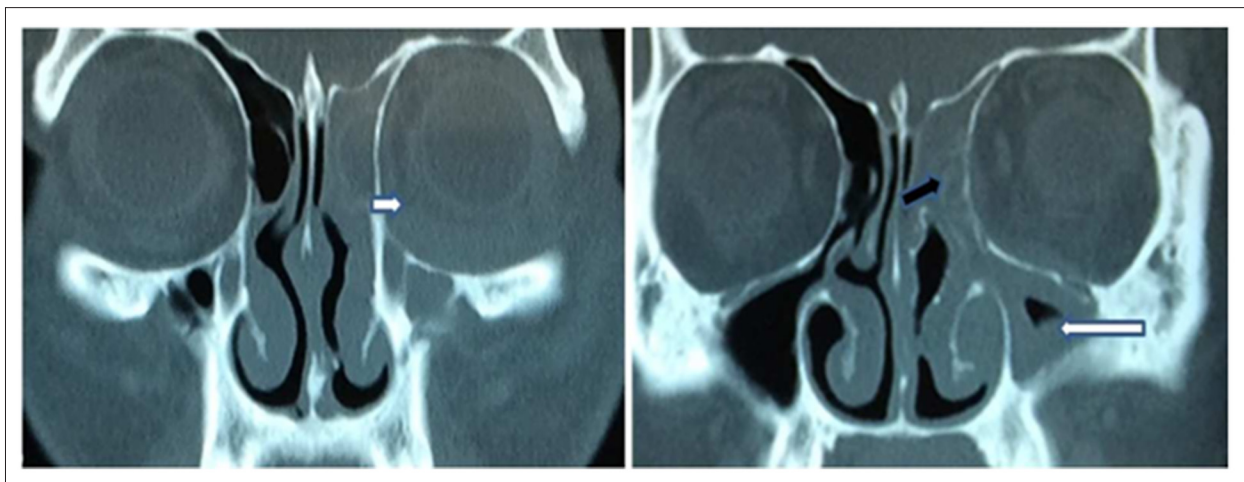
CT scan of paranasal sinuses demonstrating preseptal orbital edema (small white arrow), opacification of left maxillary (long white arrow), and anterior ethmoidal (black arrow) sinuses.
